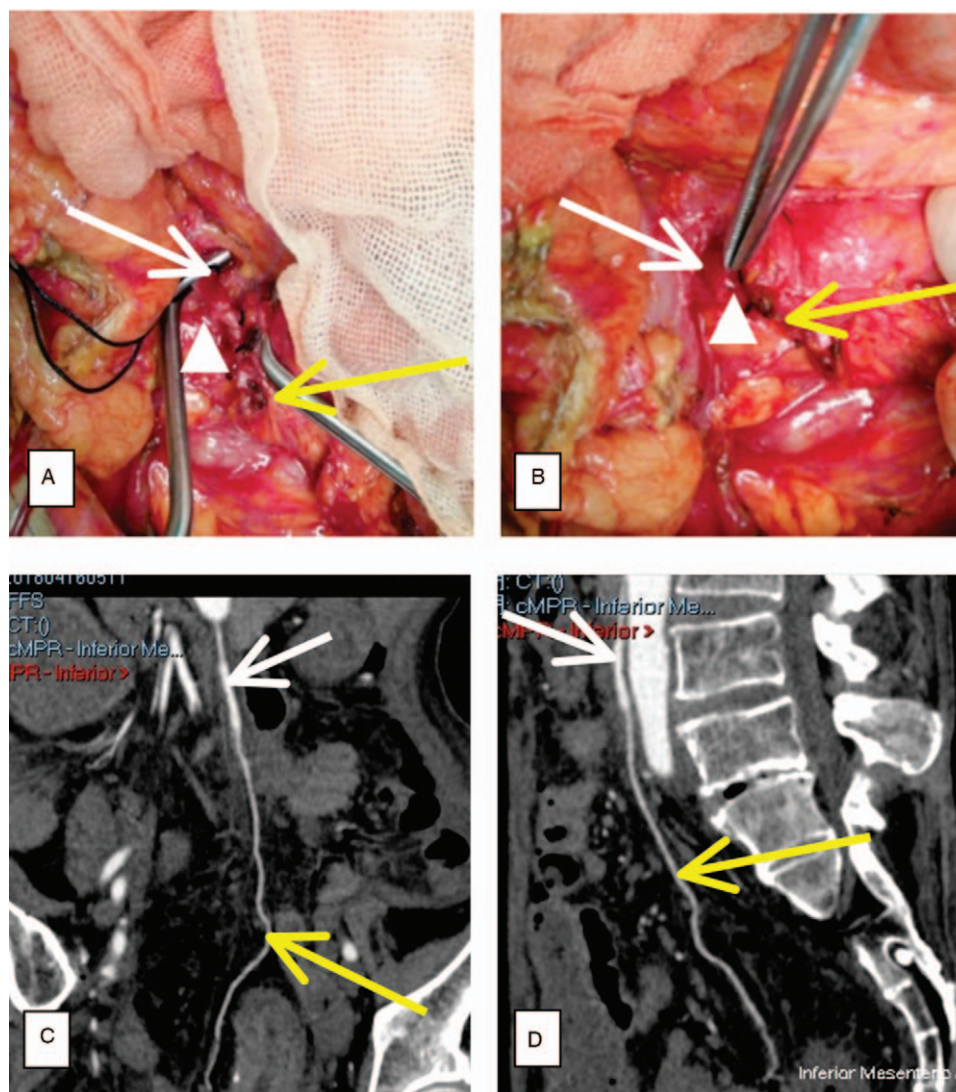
Blood vessels anastomosis. A and B: During the procedure, the ileal branches of the ileocolic artery and vein were preserved. Ileocolic artery root was liberated (yellow arrow) and its ileum branches parts were reserved. Inferior mesenteric artery (white arrow) was liberated to sacral promontory level. The ileocolic artery was anastomosed with the distal stump of inferior mesenteric artery (the anastomosed site showed with triangle). C and D: On 14 days after the operation, the CTA showed complete patency of inferior mesenteric-ileocolic artery. Blood of pouch originated from both superior mesenteric artery and inferior mesenteric artery.
